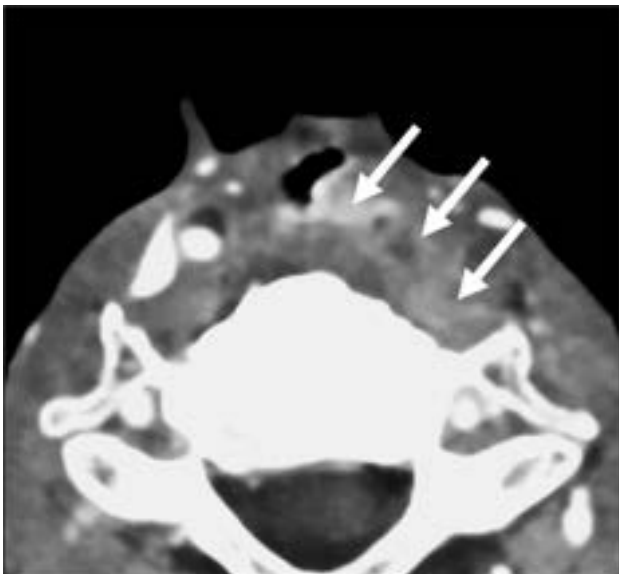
A 67-year-old man with a history of laryngeal SCCA, status post laryngectomy and radiation, and dilation of multiple sites of neopharyngeal and esophageal stenosis presented with obstruction and severe neck pain. An axial contrast-enhanced image demonstrates a fluid-filled sinus tract from the neopharyngeal posterior wall, extending to thickened prevertebral soft tissues (arrows). MR imaging of the cervical spine revealed characteristic cervical diskitis/osteomyelitis at multiple levels (not shown).
